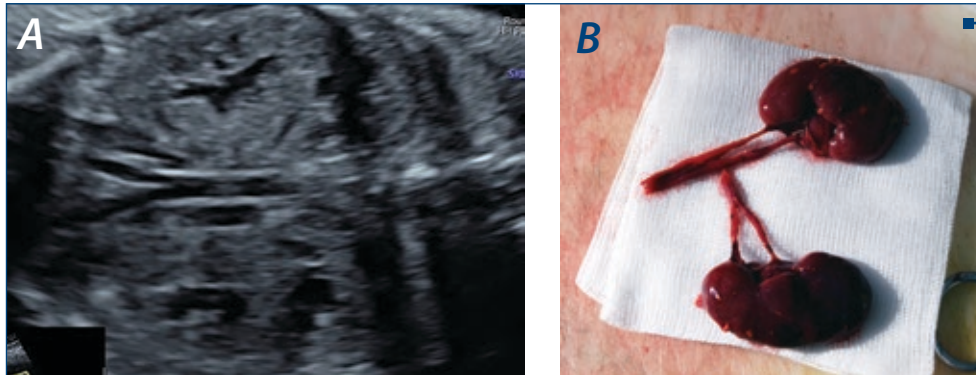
(A and B). Duplex kidneys; note the ultrasound aspect with dilated ureter
